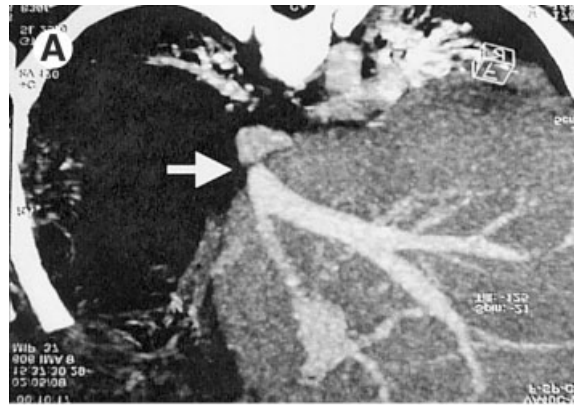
(A) CT angiography shows stenosis of the hepatic vein at the anastomosis (white arrow; \hat{u}). (2B) Transjugular hepatic venography shows stenosis of the hepatic vein at the anastomosis (white arrow; \hat{u}) similar to the CT angiographic picture.
